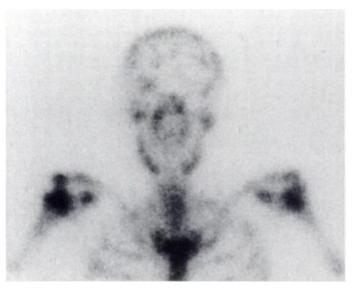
Bone scintigram reveals metastatic involvement of the mandibula in Patient 2.
